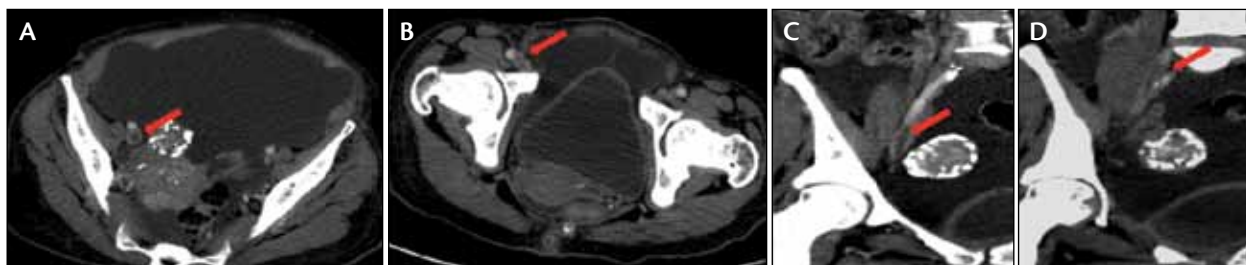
Axial (A, B) and coronal (C, D) images from CT venography show extensive right iliofemoral DVT in this patient with chronic liver disease.
